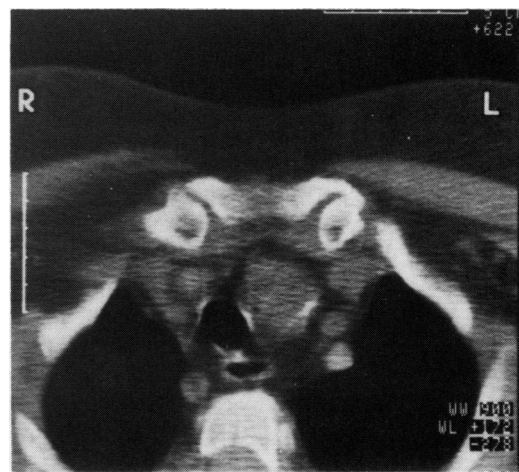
Computed tomography scan of the sternoclavicular joint showing capsular calcification of the left sternoclavicular joint.
